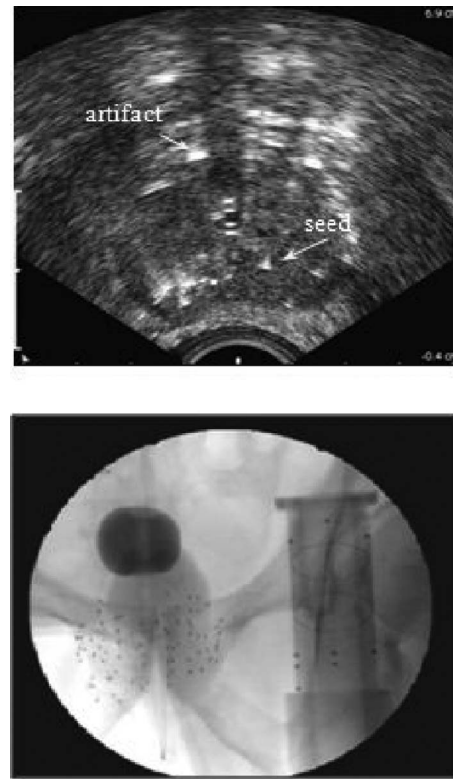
(Top) Transrectal ultrasound shows a faint trace of the prostate contour, some of the implanted seeds, and various imaging artifacts. (Bottom) C-arm fluoroscopy images are acquired during the intervention to qualitatively validate seed positions. The prostate is not visible in fluoroscopy.
